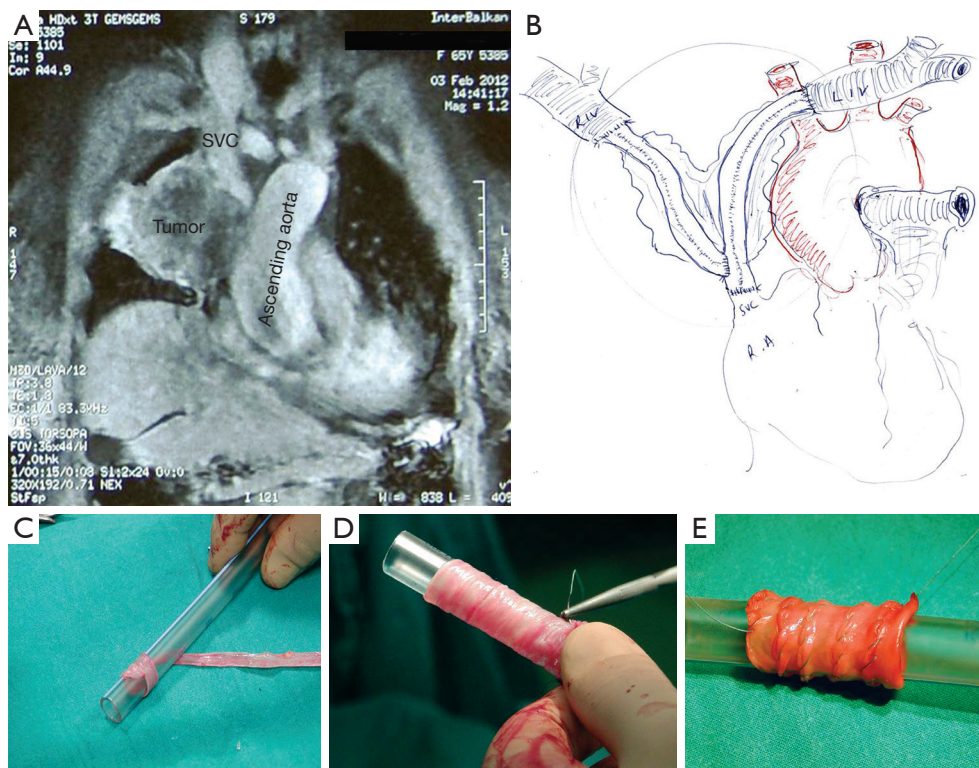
Superior vena cava (SVC) invasion resection and reconstruction with native venous-graft. (A) Tumor invading the SVC (chest MRI—coronal view); (B) handmade sketch of SVC and anonymous reconstruction with native graft constructed by saphenous vein; (C,D,E) stages of native venous-grafts construction by saphenous vein. MRI, magnetic resonance imaging.
